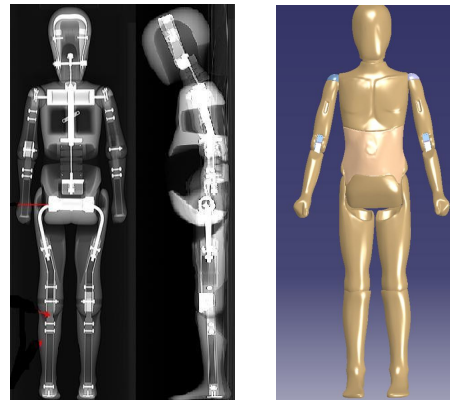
P10 (*P10 base*) dummy x-rayed in 2 views (left) and 3d-Catia model of the total assembly (right).
